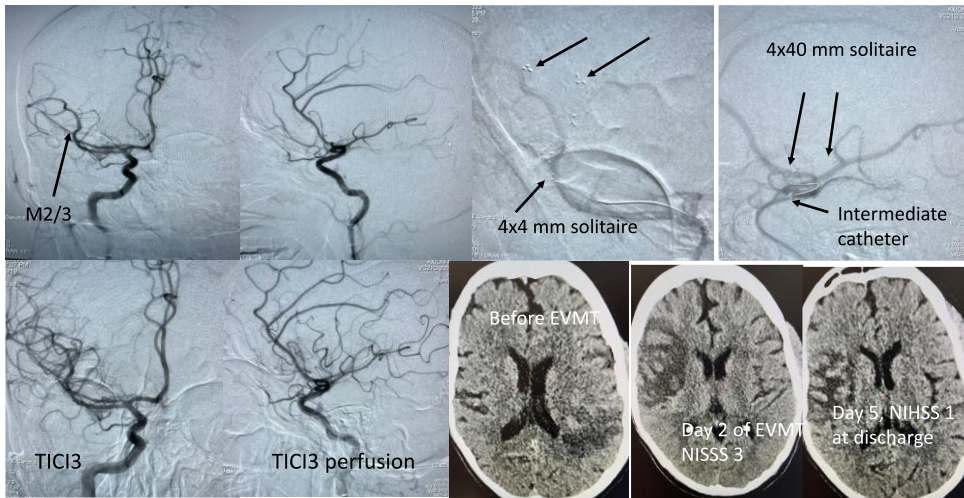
55 Y/O women with metabolic syndrome , last known normal 30 minutes ago, transferred from a rural hospital, NIHSS 25 and GWNS, indicative of LVO. CT ASPECT 5, directly went for EVMT without CTA/CTP. Angiogram demonstrated left ICA-T clot, TIC13 perfusion achieved with stent retriever device, balloon guide and an intermediate catheter using TRAP technique
